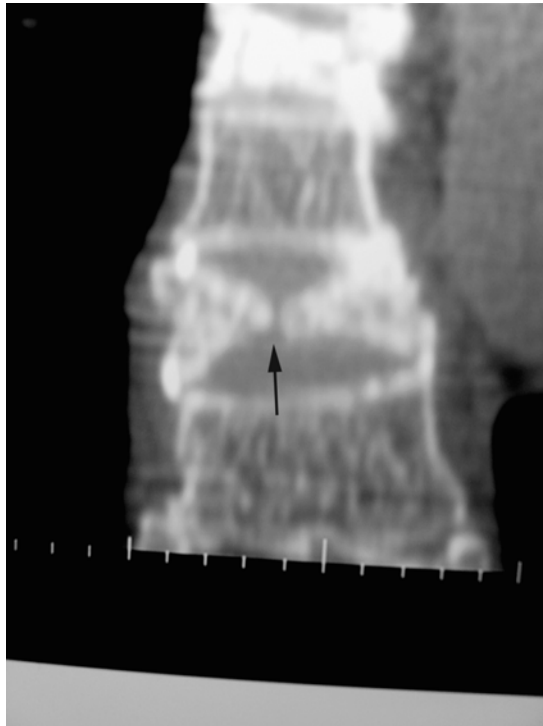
A sagittal CT reconstruction demonstrates the vertical fracture that separates the anterior and posterior vertebral body (black arrow).
